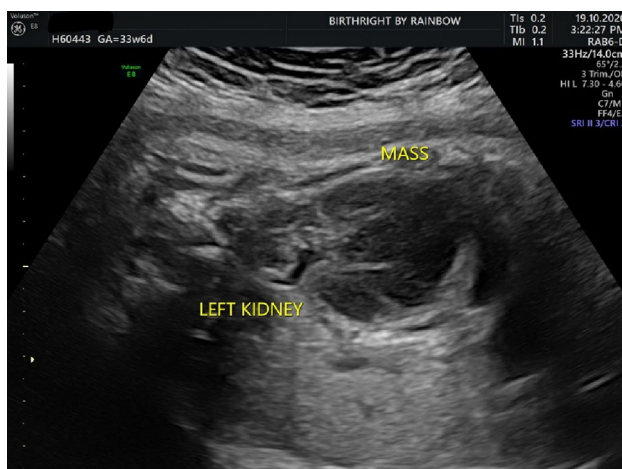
Ultrasound picture of fetal renal mass
